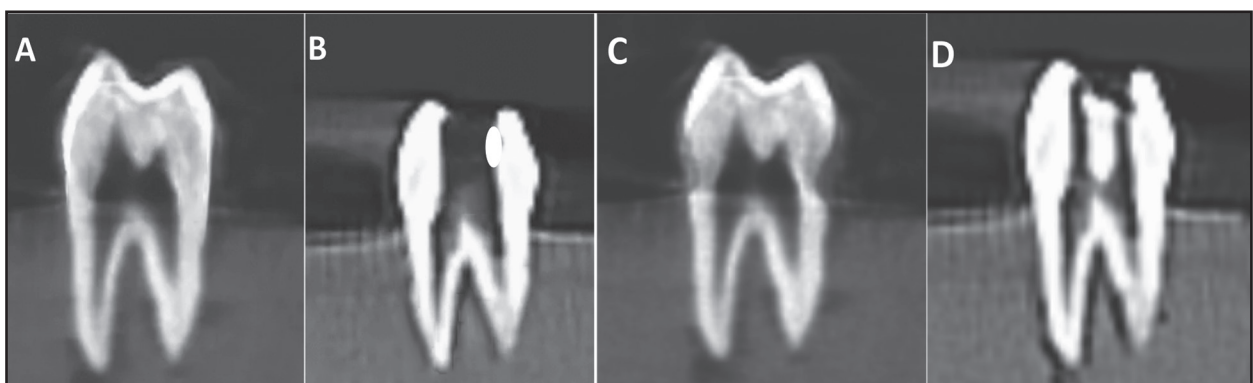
CBCT photographs showing the volume of dentine removed (A and B) A tooth before and after traditional access cavity (TAC), (C and D) A tooth before and after conservative access cavity (CAC).
